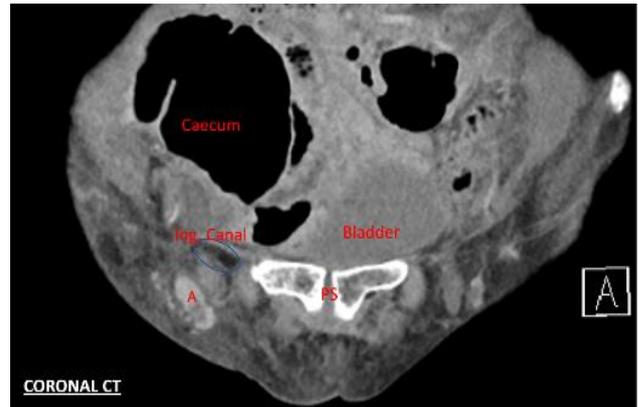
Coronal CT scan demonstrating the appendix herniating through the superficial ring of the inguinal canal.
